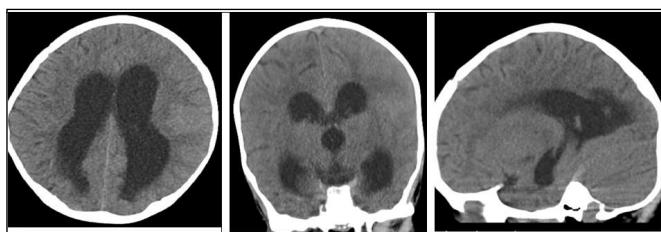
CT head showing evidence of hydrocephalus involving all the ventricles and diffuse cerebral edema in the left cerebral hemisphere close to the vertex with effacement of cortical sulci and gyri. The possibility of impending ischaemia in left cerebral hemisphere cannot be entirely excluded.
